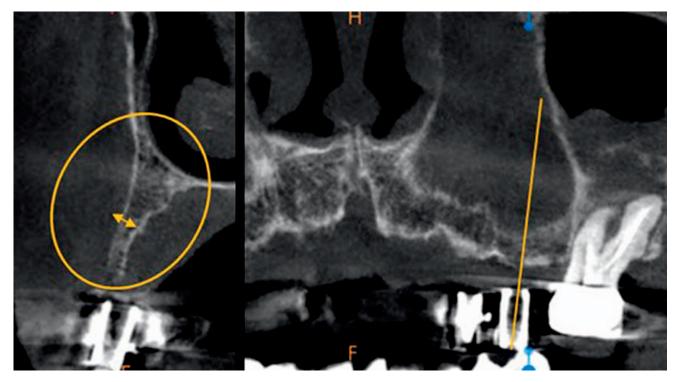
CBCT analysis of the diagnostic guide at site #13 confirms inadequate width of available bone for implant placement at the planned site.
